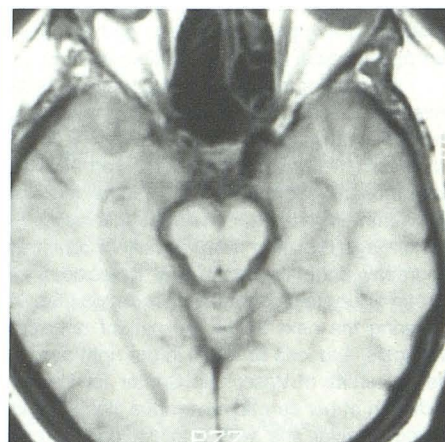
Axial MR image, 600/30, at level of cavernous sinus after occlusion of right internal carotid artery. Area of decreased signal shown in Fig. 3 now has increased signal consistent with thrombosis within giant aneurysm.
